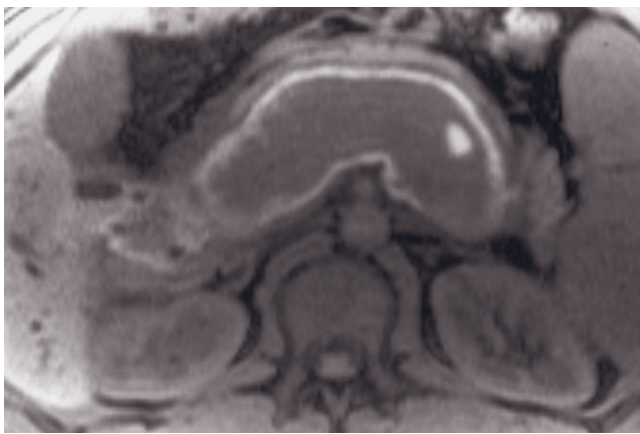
Portal and splenic vein thrombosis—subacute blood thrombus. Coronal T2-weighted SS-ETSE (*a*), coronal SGE (*b*), T2-weighted fat-suppressed SS-ETSE (*c*), SGE (*d*), fat-suppressed SGE (*e*), and 90-s fat-suppressed (*f, g, h*) postgadolinium SGE images in a 21-yr-old man who has a history of spontaneous retroperitoneal hematoma associated with portal and splenic vein thrombosis. There is marked dilatation of the splenic vein, portal vein, and proximal superior mesenteric vein, which contains
